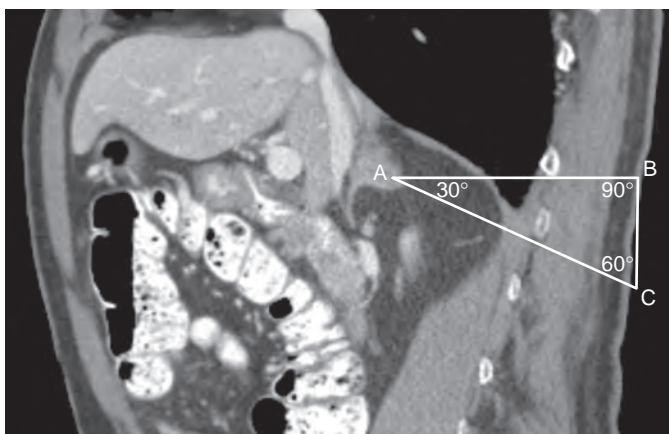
An 87-year-old man with melanoma. Parasagittal reformation of an intravenous and oral contrast-enhanced CT of the upper abdomen reveals a right adrenal mass. Because biopsy of the lesion through an axial approach would have transgressed lung, the triangulation method was used. Three points are selected: A, the lesion; B, the skin overlying the lesion; and C, a point either cranial or caudal to the lesion. The position of C was selected such that a line formed between A and C did not transgress any critical structures. These three points form a right triangle, and by trigonometry, the needle length distance and angle of insertion were appropriately calculated. Fine-needle aspiration revealed metastatic melanoma.
